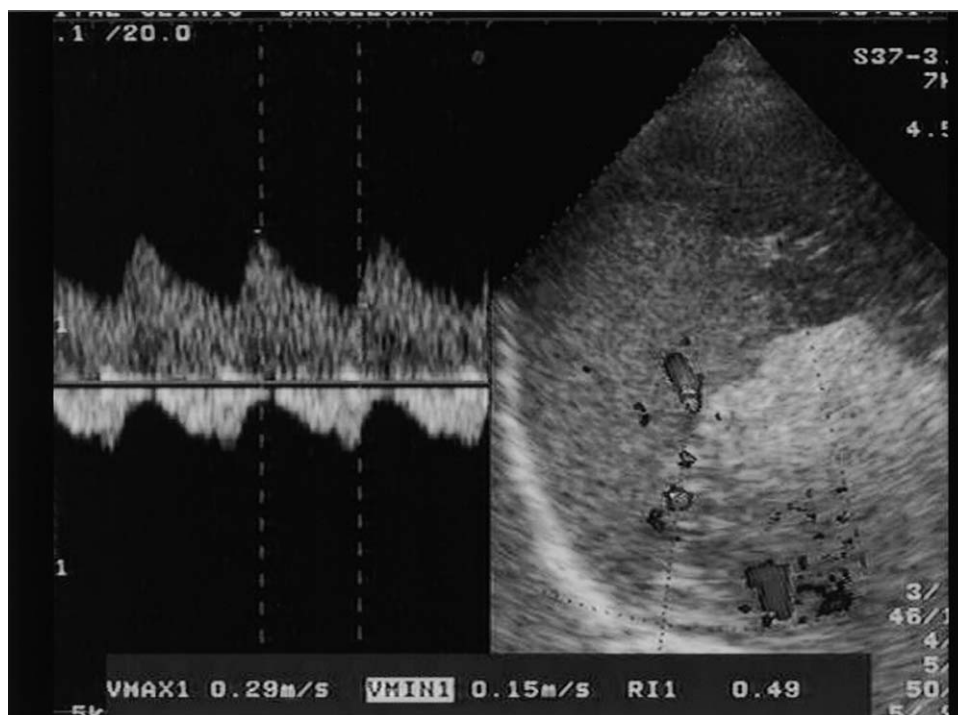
Color-Doppler ultrasound shows a hypochoic/heterogeneous area that involves the caudal part of the spleen. In the Doppler study, low-resistance arterial waveforms (infrared [IR] = 0.49) are obtained in the preserved spleen, which shows a homogeneous echostructure.
